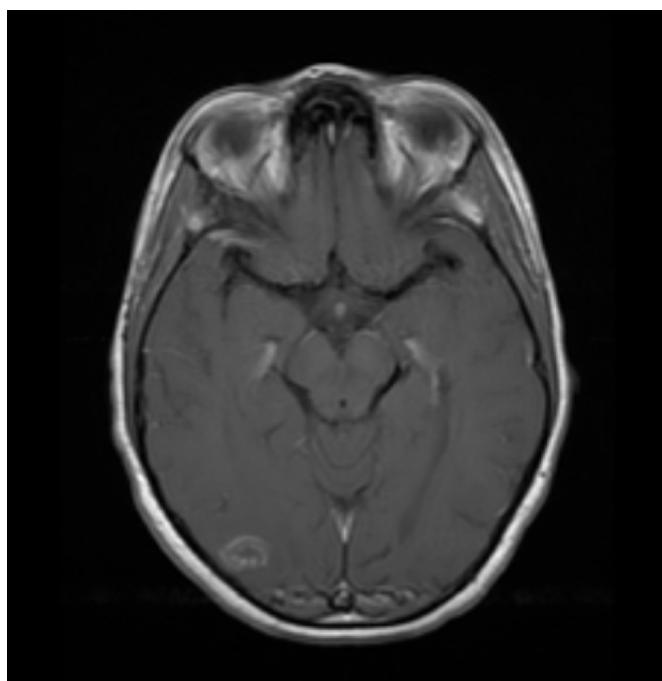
Cranioencephalic MRI (T1 axial with gadolinium contrast) nearly 2 weeks after anti-toxoplasma therapy
